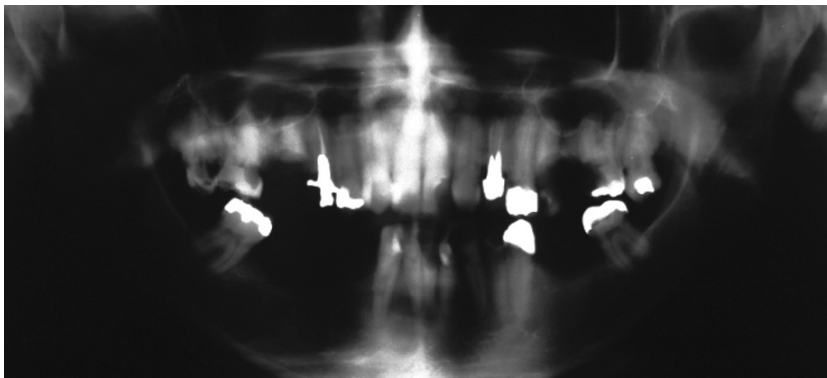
Case 3. Mandible panoramic radiograph exhibiting diffuse dental destruction due to widespread dental caries. Note the tendency of cGVHD-related caries to cause tooth crown amputation.
